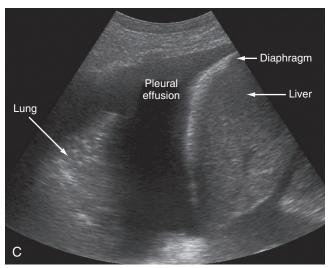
Ultrasound image of the right upper quadrant demonstrating the typical hypoechoic appearance of a pleural effusion.
